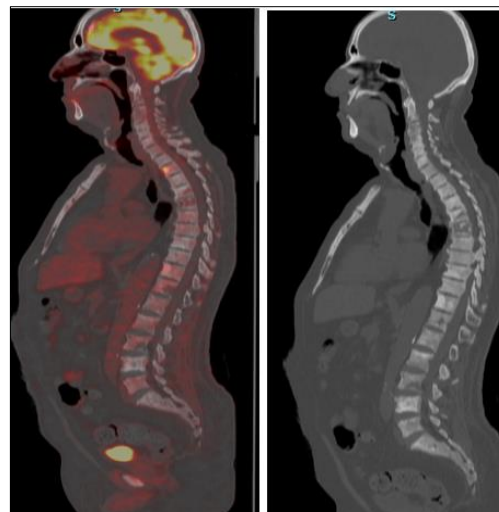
Sagittal view CT and PET CT lumbar spine with sclerotic lesions with variable grades of uptake
